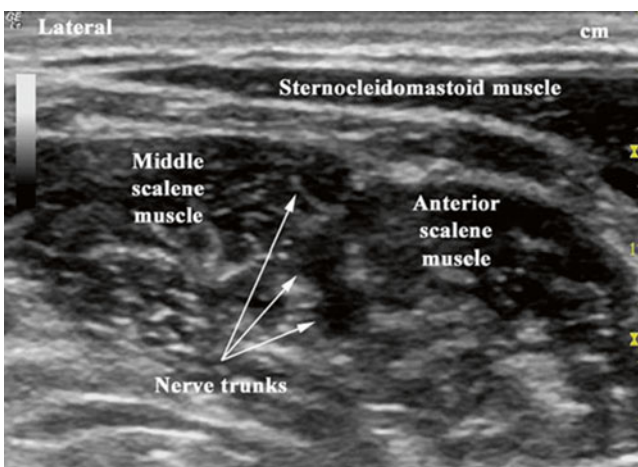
Brachial plexus trunks at the level of C6 with ultrasound (With permission from Buckenmaier and Bleckner [71])
